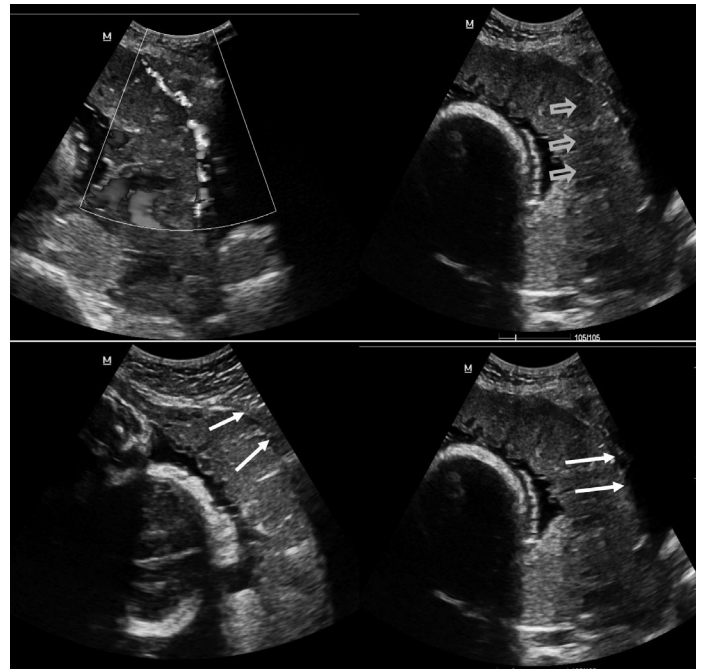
Gray-scale and color Doppler images showing sonographic diagnostic criteria for morbidly adherent placenta. Top left: Hypervascularity in posterior bladder wall. Top right: Presence of placental lacunae. Bottom left: Loss/irregularity of echolucent area located between uterus and placenta (arrows). Bottom right: Bladder line: thinning or interruption of hyperechoic interface between uterine serosa and bladder wall (arrows).
